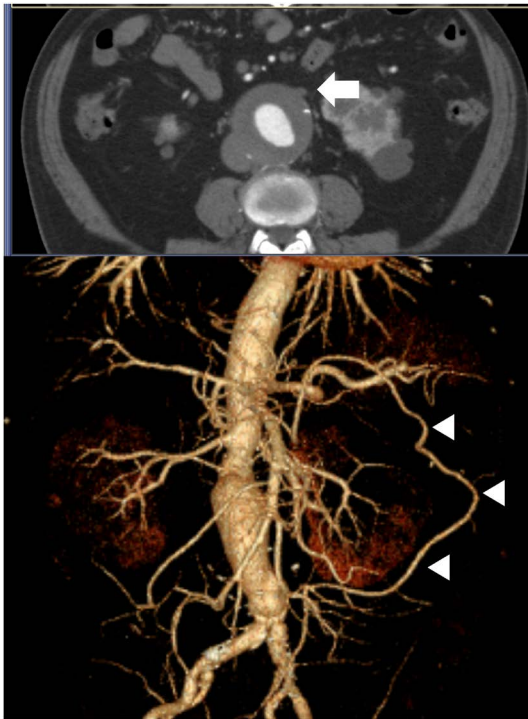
Occlusion of the orifice of the inferior mesenteric artery in a patient with infrarenal abdominal aortic aneurysm (arrow). Three-dimensional reconstruction of a computed tomographic angiogram shows the meandering mesenteric artery which provides collateral circulation between the superior and inferior mesenteric arteries (arrow heads).
